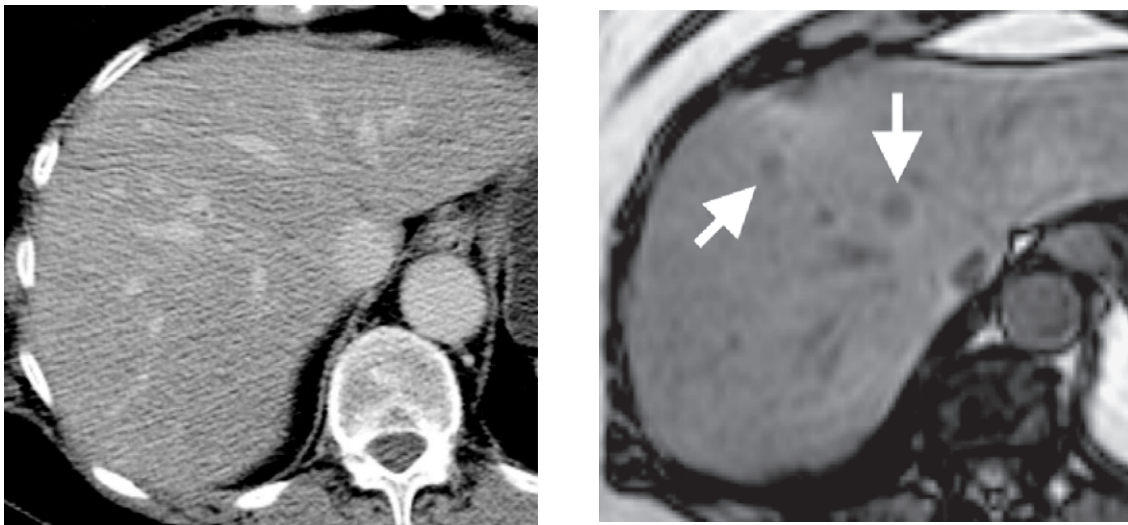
Diffuse liver steatosis can obscure liver metastases. Left: contrast-enhanced CT in the portovenous phase in a 45-year-old man shows diffuse low-density changes in the liver consistent with hepatic steatosis. Right: T1-weighted out-of-phase MR image shows signal loss in the liver parenchyma confirming fatty infiltration. However, two liver metastases (arrows) are also visible which are not seen at CT scanning.
